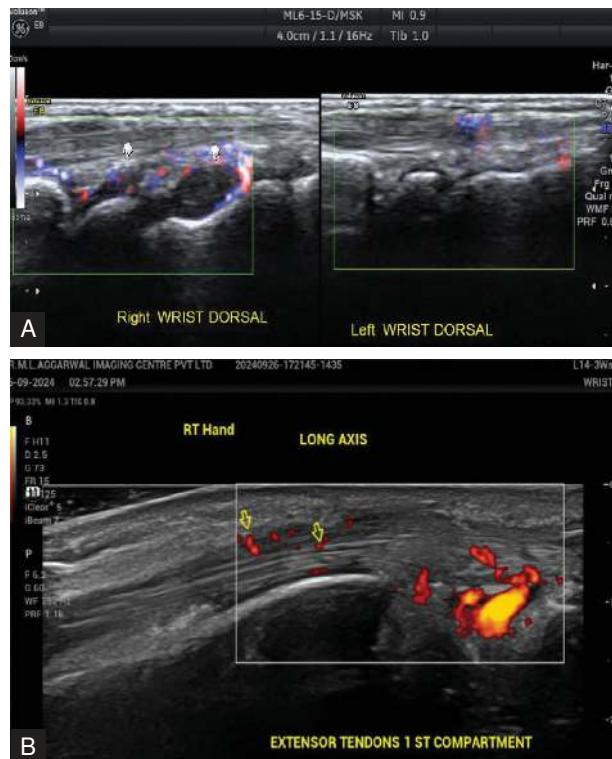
(A) POCUS of the tendons around the wrists in a patient with 'arthralgias suspicious for arthritis' (e.g. preclinical stage of rheumatoid arthritis) reveals the presence of power Doppler signals in and around the tendons, accompanied by thickened hypoechoic tissue in the tendon sheath, indicating inflammatory tenosynovitis. In cases where clinical assessment alone may not reliably confirm inflammation in the tendon sheath, POCUS serves as an early and objective tool to detect and quantify the presence of inflammatory changes. (Courtesy: Dr Raghav Aggarwal, Dr ML Aggrawal Imaging Center, New Delhi.) (B) POCUS of the dorsal aspect of the wrist joint reveals synovial hypertrophy, visible as hypoechoic tissue within the radiocarpal and intercarpal joints. These findings support the clinical suspicion of inflammatory synovitis in a patient with early-stage inflammatory arthritis (e.g. rheumatoid arthritis). (Courtesy: Dr Raghav Aggarwal, Dr ML Aggrawal Imaging Center, New Delhi.)
